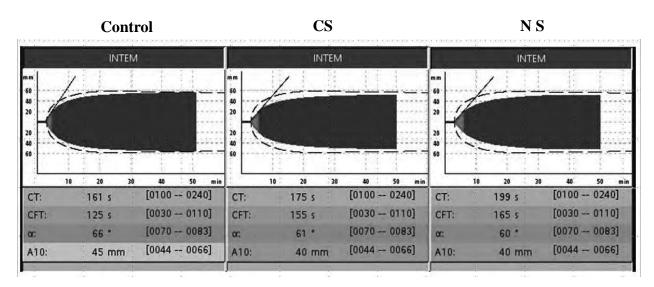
An example of typical rotation thromboelastometry traces. Clotting time (CT) and clot formation time (CFT) in SC and NS were prolonged compared to those in Control, while amplitude at 10 minutes (A10) in SC and NS were narrower than that in Control.
